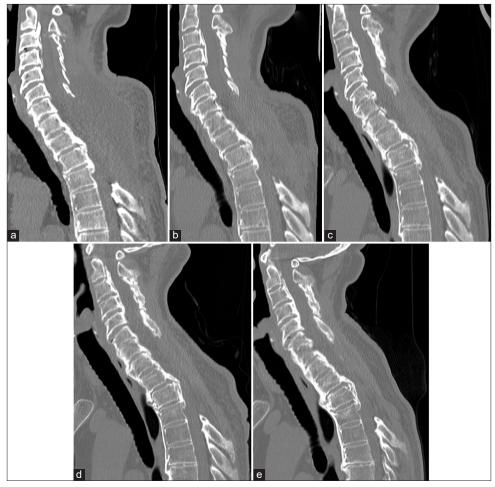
Change in CT sagittal image. CT sagittal images (a) after initial surgery and at (b) 2 years, (c) 5 years, (d) 7 years, and (e) 9 years. T1-4 kyphosis was 18.3°, 18.1°, 18.4°, 23.2°, and 28.7°, respectively, and OPLL thickness was 8.7 mm, 8.6 mm, 8.8 mm, 9.4 mm, and 11.2 mm, respectively. CT: Computed tomography, OPLL: Ossification of the posterior longitudinal ligament.
